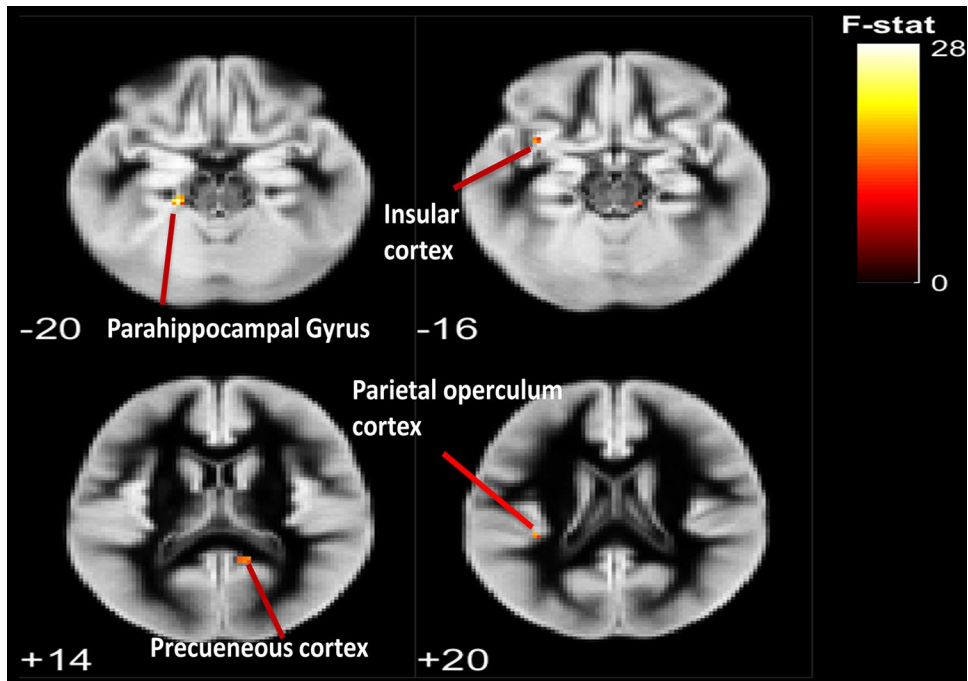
Neural underpinnings of pretask resting-state alpha frontal asymmetry through electroencephalography informing situational awareness-task-based functional magnetic resonance imaging as shown in slice montage view.
